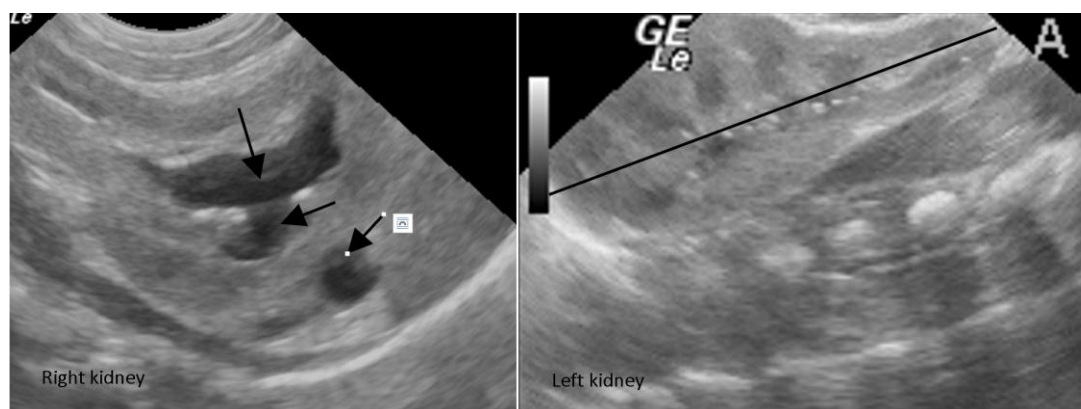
Case 3, ultrasound aspect postpartum, both kidneys.
